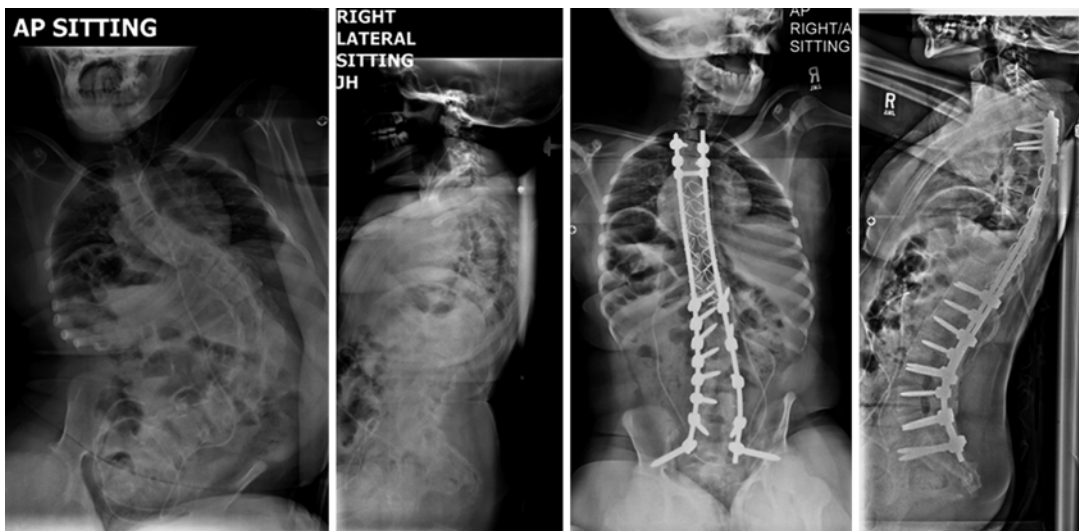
(a–d) Radiographs of a patient with quadriplegic cerebral palsy and severe scoliosis, lumbar hyperlordosis, 35° pelvic obliquity, and seating difficulties. The
